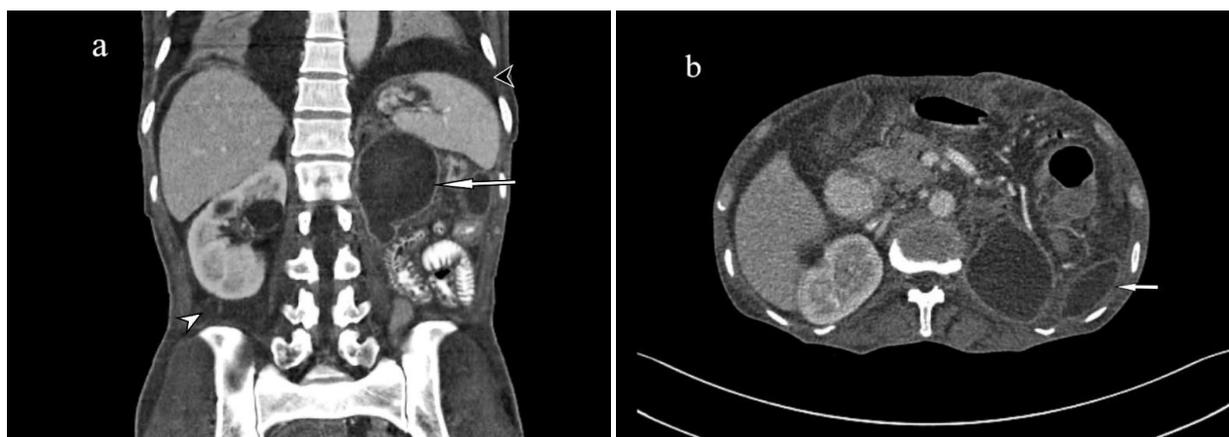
(a, b): Coronal and axial contrast enhanced CT images of patient revealed multiple peripherally enhancing pockets of loculated collection in left renal fossa (white arrow) with pleural effusion (black arrow head) and ascites(white arrow head)
